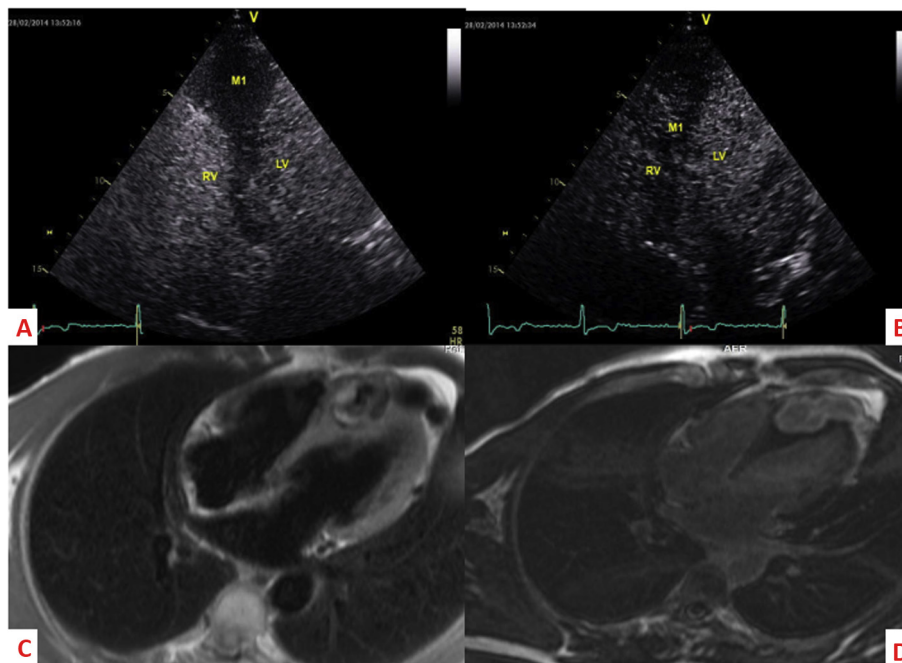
(A, B) 4-Chamber apical view contrast echocardiography. (A) Left and right ventricles opacification; (B) opacification of septal mass, 15 seconds after ventricles opacification; (C) 4-chamber view cardiac magnetic resonance imaging, black blood sequence; and (D) gadolinium delayed enhancement sequence. LV = left ventricle; M1 = septal cystic mass; RV = right ventricle.
